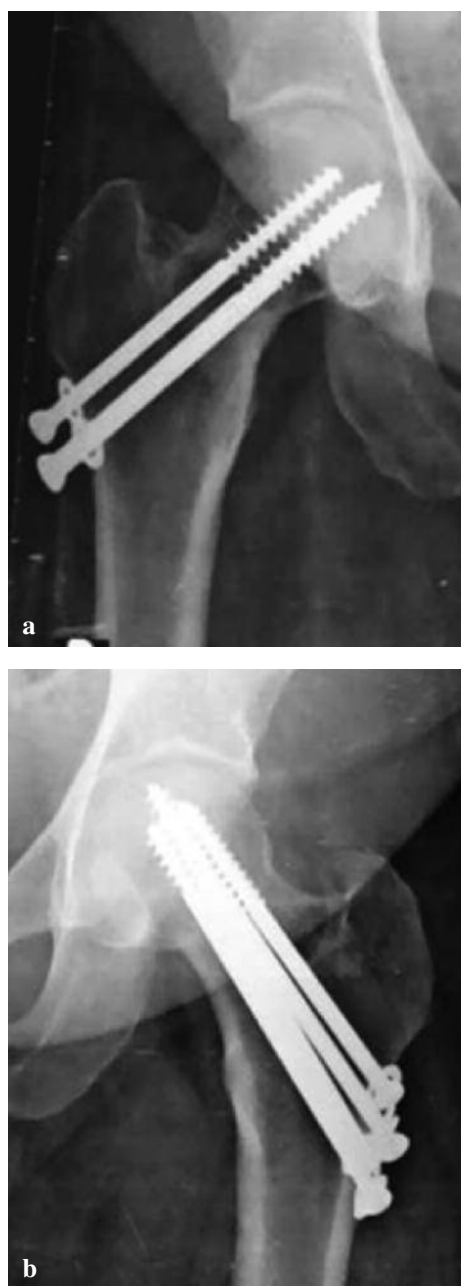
a & b. — AP radiographs of both hips showing fracture union without any sign of AVN 29 months after internal fixation.
